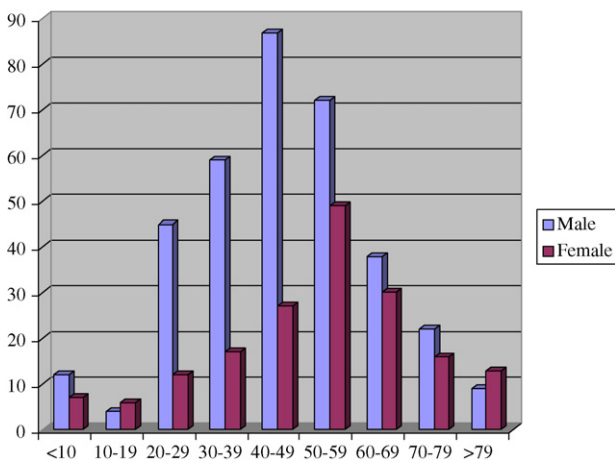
Sex and age in CT-scanned material.
